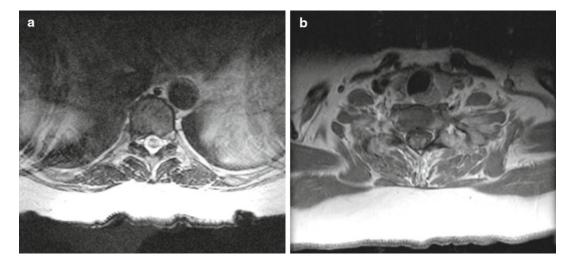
Signal change in the central cord and lateral columns caused by paraneoplastic myelitis in the setting of renal cell carcinoma. (a) Axial T2 MRI. (b) Axial T1 MRI with gadolinium
